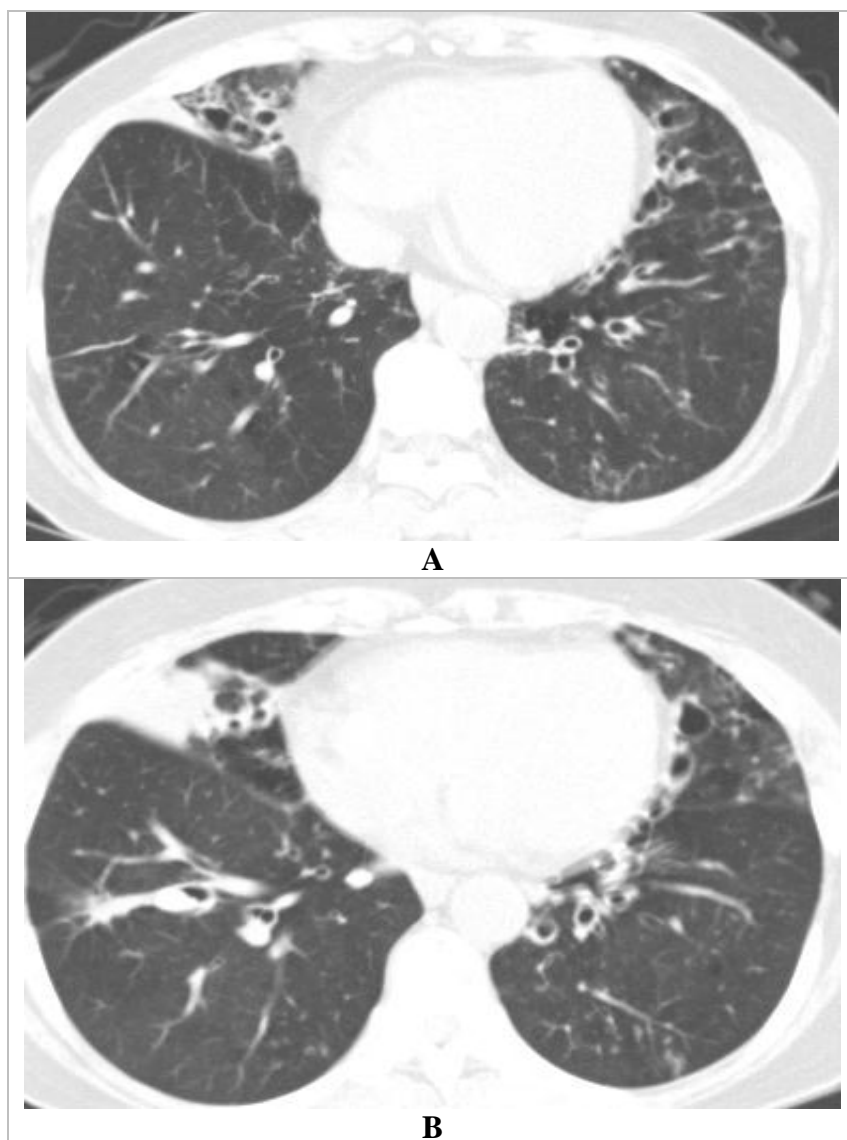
Chest CT findings of patient No.3 in whom rare NTM of *M. phocaicum* and *M.mageritense* were isolated.
